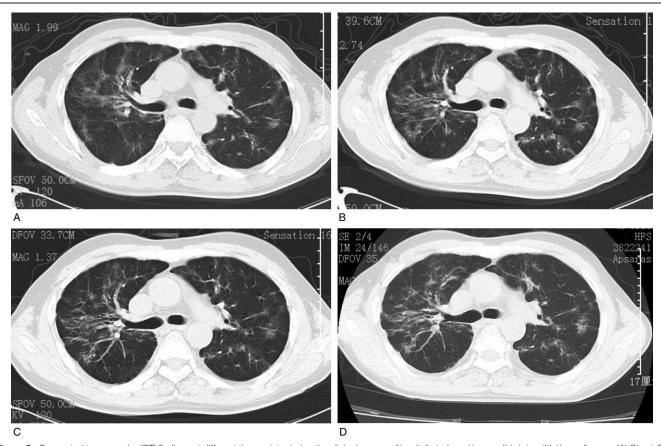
Computed tomography (CT) findings at different time points during the clinical course of imatinib-induced irreversible interstitial lung disease. (A) Chest CT performed at the time of the first presentation (9 months after imatinib treatment initiation) shows dense cord-shaped or grid-shaped fibers distributed along the surrounding bronchi, indicating fibrosis. The bilateral lungs, particularly the upper lobes, are involved. These findings are typical of interstitial pneumonia. (B) CT performed 2 weeks after treatment with antibiotics and prednisone shows little improvement. (C) CT performed 9 months after the patient was diagnosed with pulmonary fibrosis shows no improvement.
